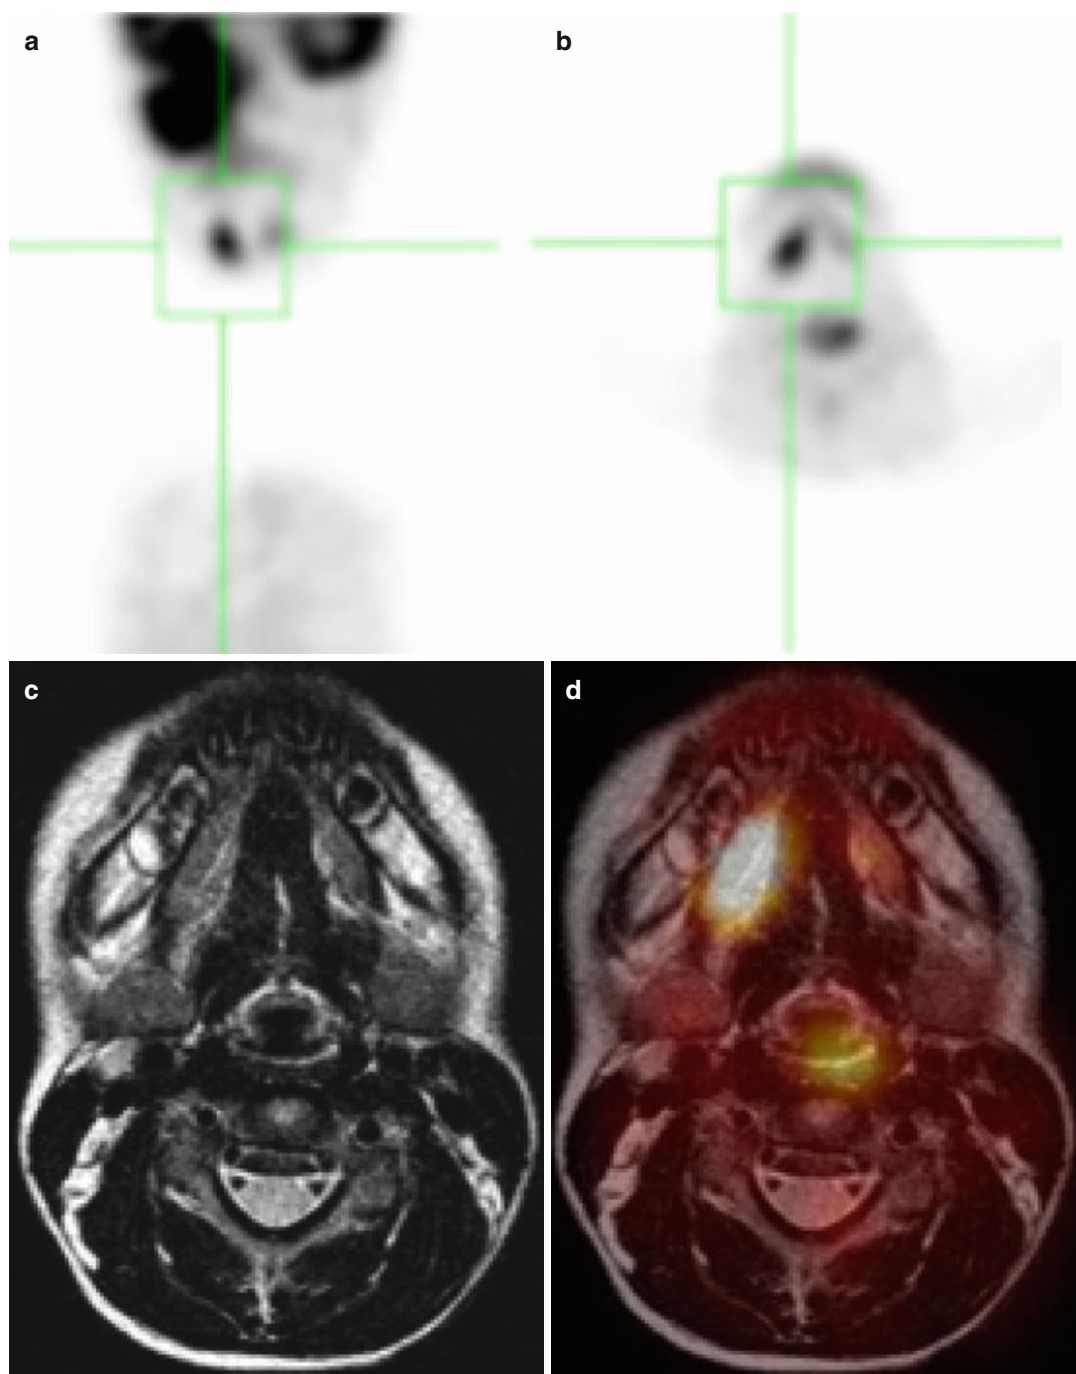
A 5½-year-old girl with rhabdomyosarcoma – false positive on ^{18}F -FDG PET. At primary diagnosis, ^{18}F -FDG PET (a–b) shows an increased uptake in the submandibular region. A lymph node metastasis of the rhabdomyosarcoma was suspected. On the MRI
